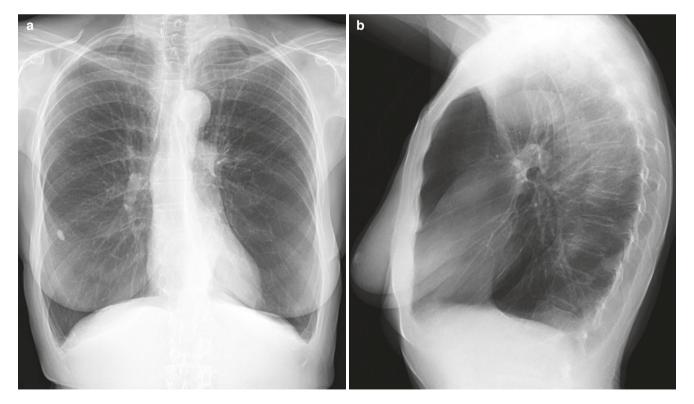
Panlobular emphysema in an elderly lady with alpha-1 antitrypsin deficiency. (a, b) Frontal and lateral chest radiographs show overinflated lungs and the paucity of vascular markings in lower lungs. (c-e)
